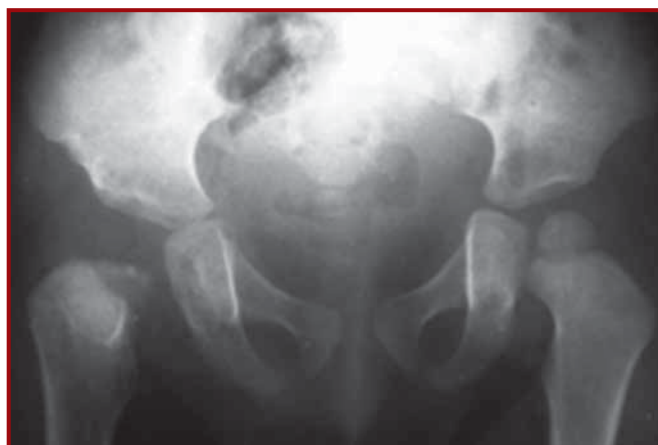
At the last follow-up visit 12 months after the operation, radiograph of the pelvis demonstrates a reduced, reossified and deformed femoral head, short but remodeled femoral neck, and mild acetabular dysplasia on the right side (Choi type IIA sequela)
